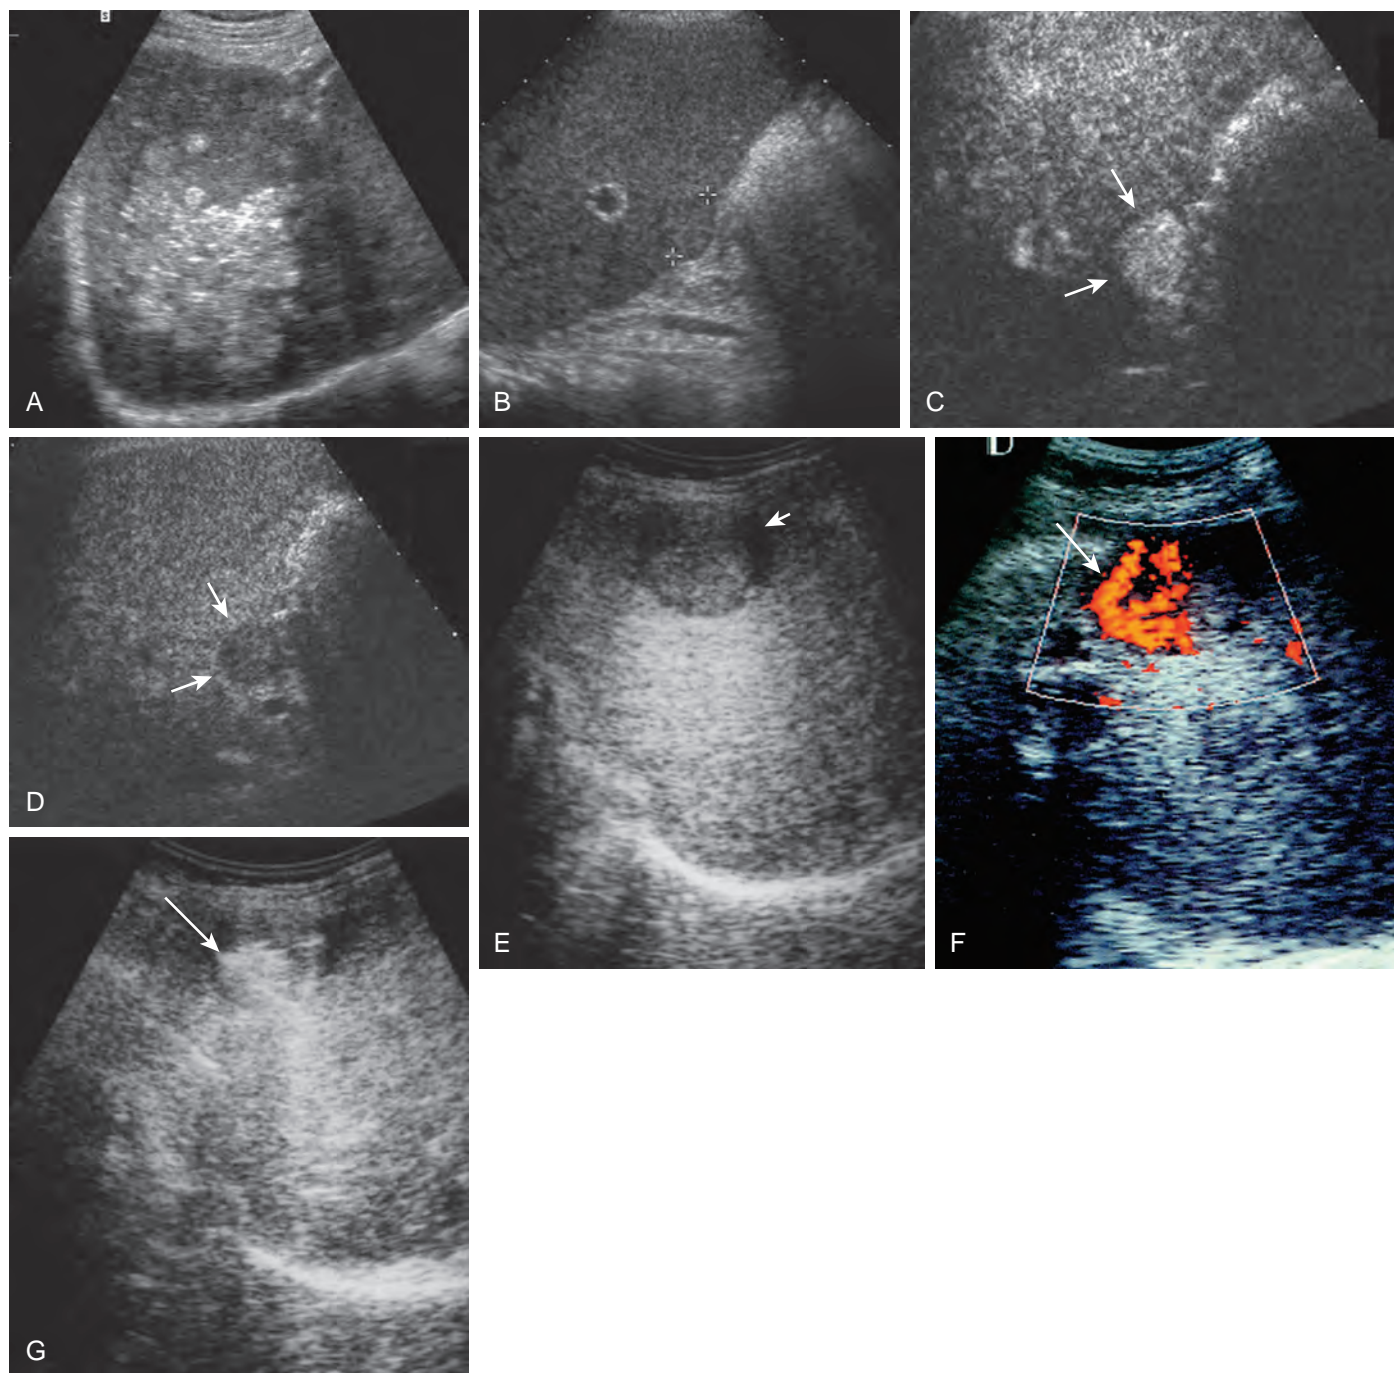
HCC: sonographic features. A. The neoplasm is strikingly echogenic in this patient. Because of variable amounts of hemorrhage and necrosis, this tumor can have a variety of sonographic appearances. B-D. Dynamic contrast-enhanced sonographic images of the liver of 70-year-old man with segment V hepatocellular carcinoma (diameter, 2.3 cm). Baseline sonographic image (B) shows focal hypoechoic hepatocellular carcinoma in right hepatic lobe (cursors delineate margins of the tumor). Arterial phase image after the injection of microbubbles (C) shows homogeneous enhancement of the lesion (arrows point to margins of the tumor). Late portal phase image (D) obtained at 180 seconds shows that the HCC is clearly hypoechoic with respect to surrounding liver. E-G. Hepatocellular carcinoma in 59-year-old man. Unenhanced gray-scale sonogram (E) shows peripheral halo sign (arrow). Power Doppler sonogram (F) shows heterogeneous vascularity (arrow). Early-phase carbon dioxide-enhanced sonogram (G) shows vascularity (arrow) similar to that seen in F. (B-D from Nicolau V, Vilana R, Catalá V, et al: Importance of evaluating all vascular phases on contrast-enhanced sonography in the differentiation of benign from malignant focal liver lesions. *AJR Am J Roentgenol* 186:158–167, 2006. E-G from Chen R-C, Chen W-T, Tu H-Y, et al: Assessment of vascularity in hepatic tumors: Comparison of power Doppler sonography and intraarterial CO₂-enhanced sonography. *AJR Am J Roentgenol* 178:67–73, 2002. Reprinted with permission from the American Journal of Roentgenology.)
